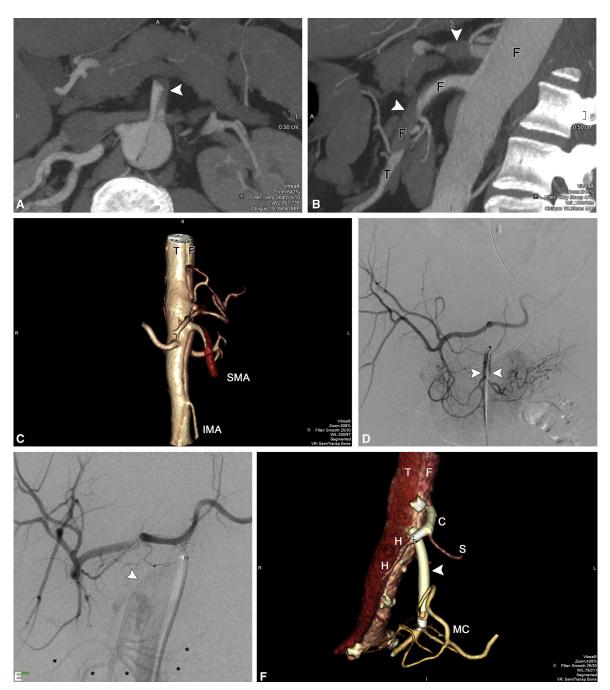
Computed tomography (CT) angiogram of a 55-year-old man with an ATBAD and static malperfusion of the celiac artery and SMA before and 8 years after endovascular fenestration/stenting. Axial CT at the level of the SMA (A) shows thrombosed false lumen (arrowhead) just beyond the SMA origin. Sagittal CT of the upper abdomen through the false lumen of the aorta (B) again shows thrombus in the terminal portion of the false lumen of the celiac trunk and the SMA, resulting in arterial occlusion. Three-dimensional reconstruction of the abdominal aorta (C) shows the dissection flap cleaving the celiac and SMA origins with thrombosed false lumen (red), with the inferior mesenteric artery (IMA) supplied by the false lumen. Superior mesenteric arteriogram (D), approximately 28 hours after symptom onset, shows proximal occlusion of the SMA trunk (arrowheads), absent filling of jejunal and ileal branches, and retrograde filling of the celiac distribution through pancreatic collaterals. After stenting of the SMA and celiac trunk, distal SMA pressure was 57/43 mm Hg, 32 mm Hg lower than aortic true lumen pressure. Sheath injection at the celiac origin after stenting (E) fills hepatic and splenic arteries and refluxes into the abdominal aorta, filling stented SMA (arrowhead) with jejunal and ileal branches (asterisks). CT with 3-dimensional reconstruction 8 years later (F) shows the celiac artery (C) stent extending into the common hepatic artery (H) with jailed but patent splenic artery (S). The SMA stent (arrowhead) is patent down to the ileocolic artery. Several small jejunal and ileal branches continue to fill through stent interstices. A prominent IMA (not shown) supports flow through the middle colic (MC) artery. F, False lumen; T, true lumen; SMA, superior mesenteric artery; IMA, inferior mesenteric artery; H, hepatic artery; S, splenic artery.
